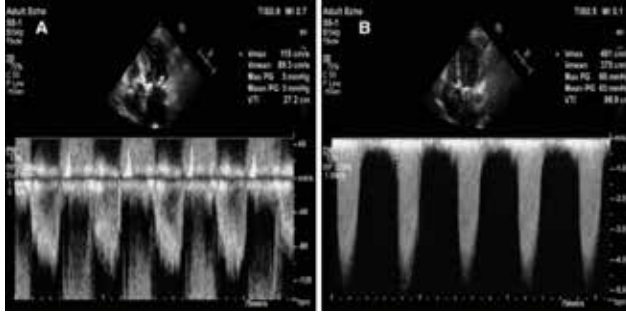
(A, B) Pre-operative transthoracic echocardiography shows LVOT and transvalvular aortic gradients.
